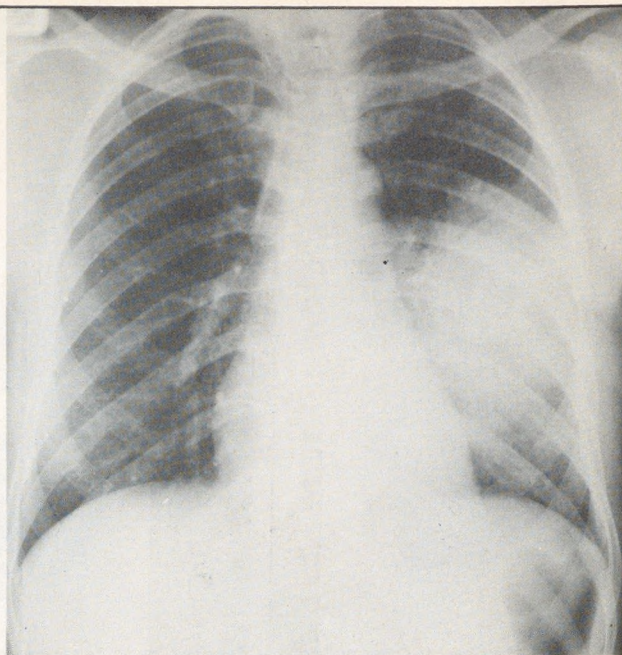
Lobar pneumonia secondary to *Hemophilus influenzae* pneumonia may resemble lobar pneumococcal pneumonia. This is a radiograph of a patient with *Hemophilus influenzae* pneumonia showing dense infiltrate at the left mid-lung field.
